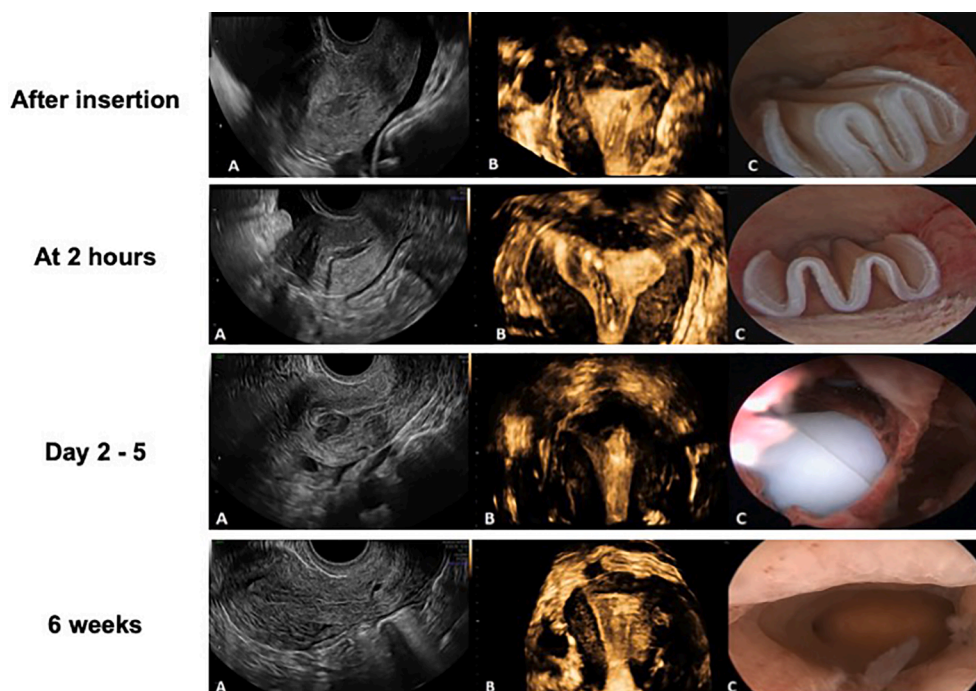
2D ultrasound (A), 3D ultrasound (B) and hysteroscopic (C) images showing the appearance of Womed Leaf at the first three follow-up time-points and the appearance of the uterine cavity at 6 weeks after the film was totally discharged.
